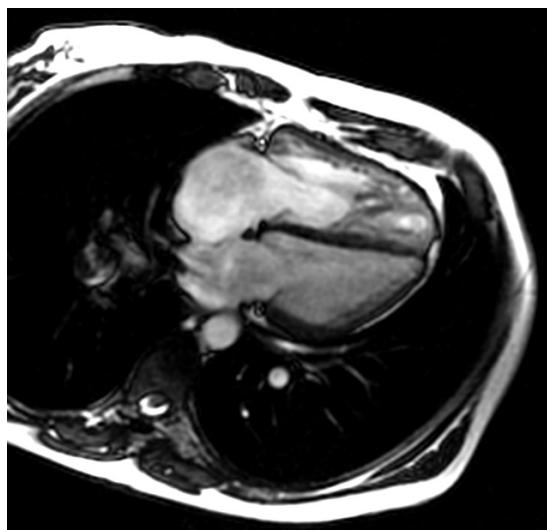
Cardiac magnetic resonance imaging showing interatrial communication.
